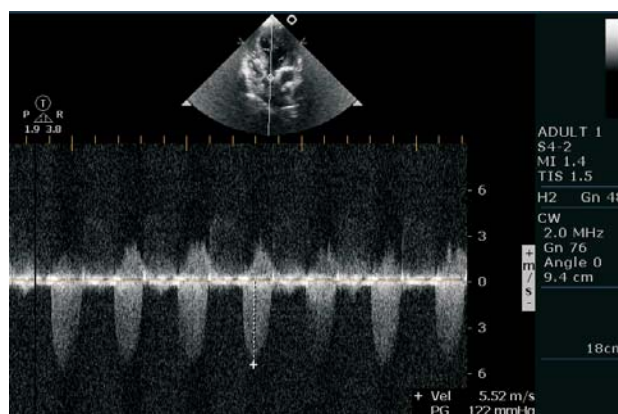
Continuous Doppler echocardiography showing gradient across LVOT.
